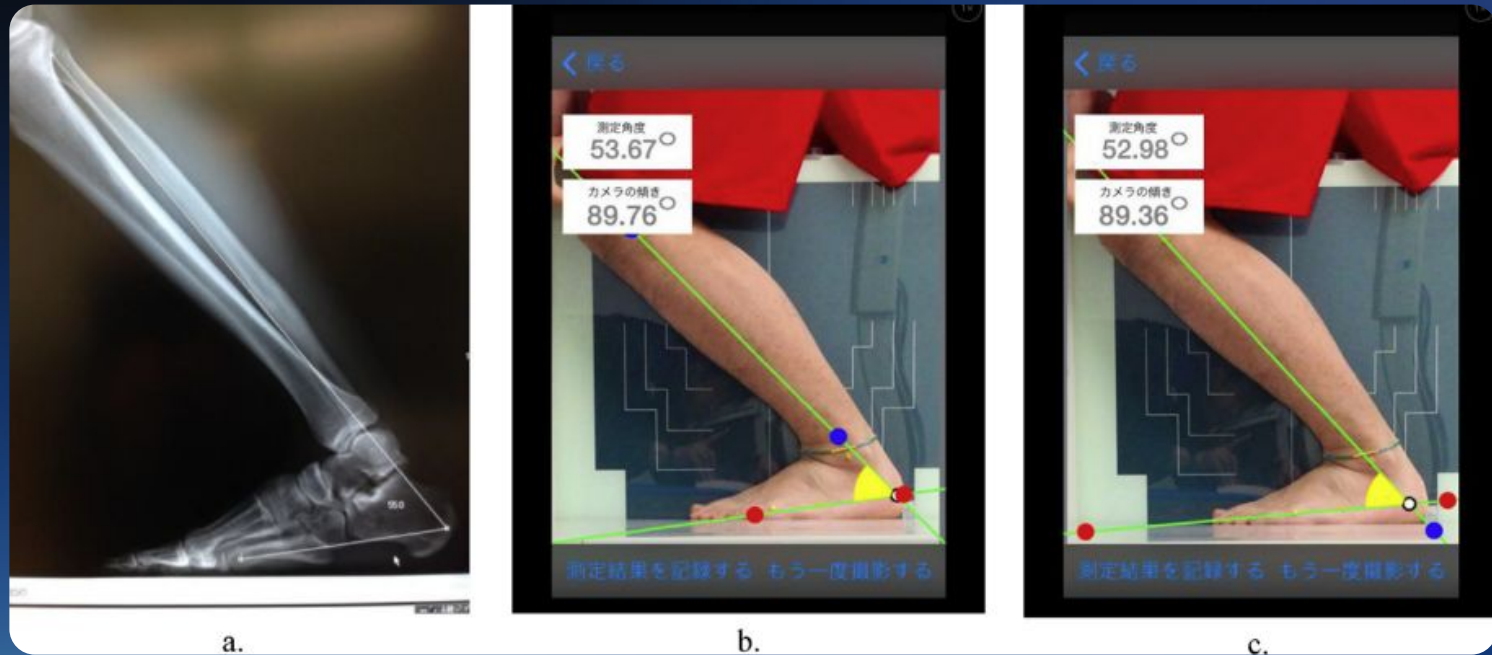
Radiographic and smartphone application measurements.
